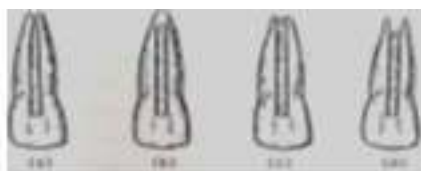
Various types of root closure in apexification. (A) Continued closure of canal and apex to a normal configuration. (B) Apex closes but canal remain with blunderbuss configuration. (C) No radiographic change, but a thin osteoid line barrier provides a definite step at or near apex. (D) Radiographic evidence of a barrier short of apex.¹⁰
